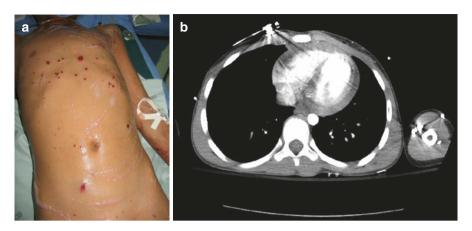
(a) An 11-year-old male with multiple peppering wounds to the chest following a mine blast injury. He maintained hemodynamic stability, and FAST exam was initially equivocal. (b) Subsequent chest CT showed hemopericardium. He underwent sternotomy and repair of small right ventricular laceration
